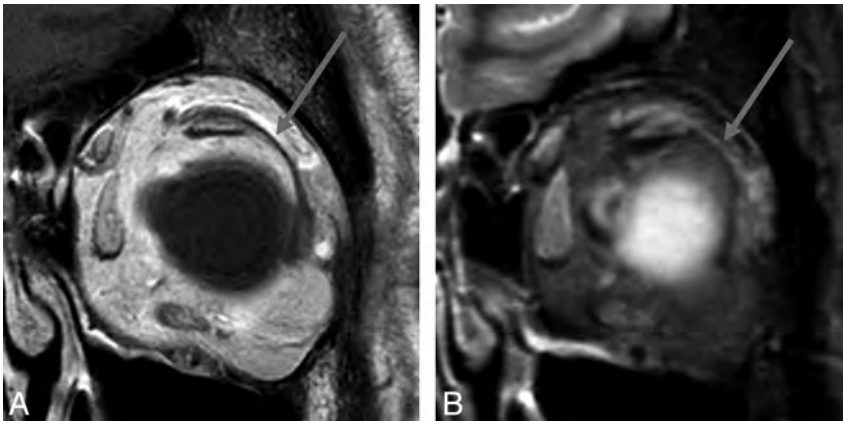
MR imaging appearance of the LR-SR band in a 44-year-old woman. Coronal T1-weighted image (A) and coronal STIR image (B) of the left orbit demonstrate the LR-SR band (arrows) as a curvilinear structure extending from the superior margin of the lateral rectus muscle to the lateral margin of the superior rectus/levator palpebrae superioris muscle complex.
